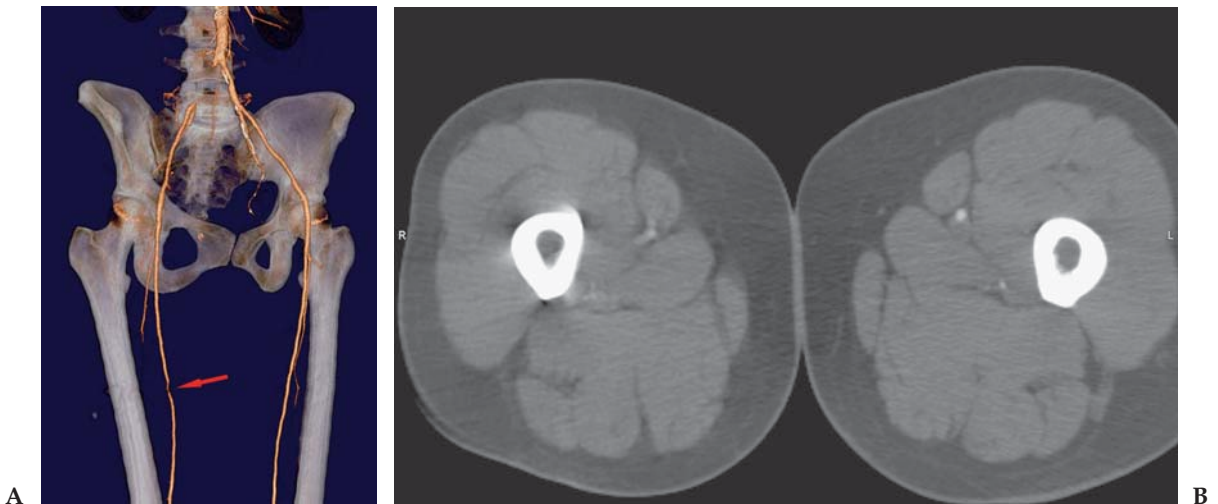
Pseudostenosis of right superficial femoral artery (SFA). (A) Volume-rendered image from a CT runoff study. The right common iliac artery is occluded. There is also an apparent high-grade stenosis of the mid right superficial femoral artery. (B) Axial 1.0-mm image. There is motion of the right leg that occurred resulting in the apparent stenosis of the SFA. Note the streak artifact from the femur and the different sharpness between the right and left legs.
